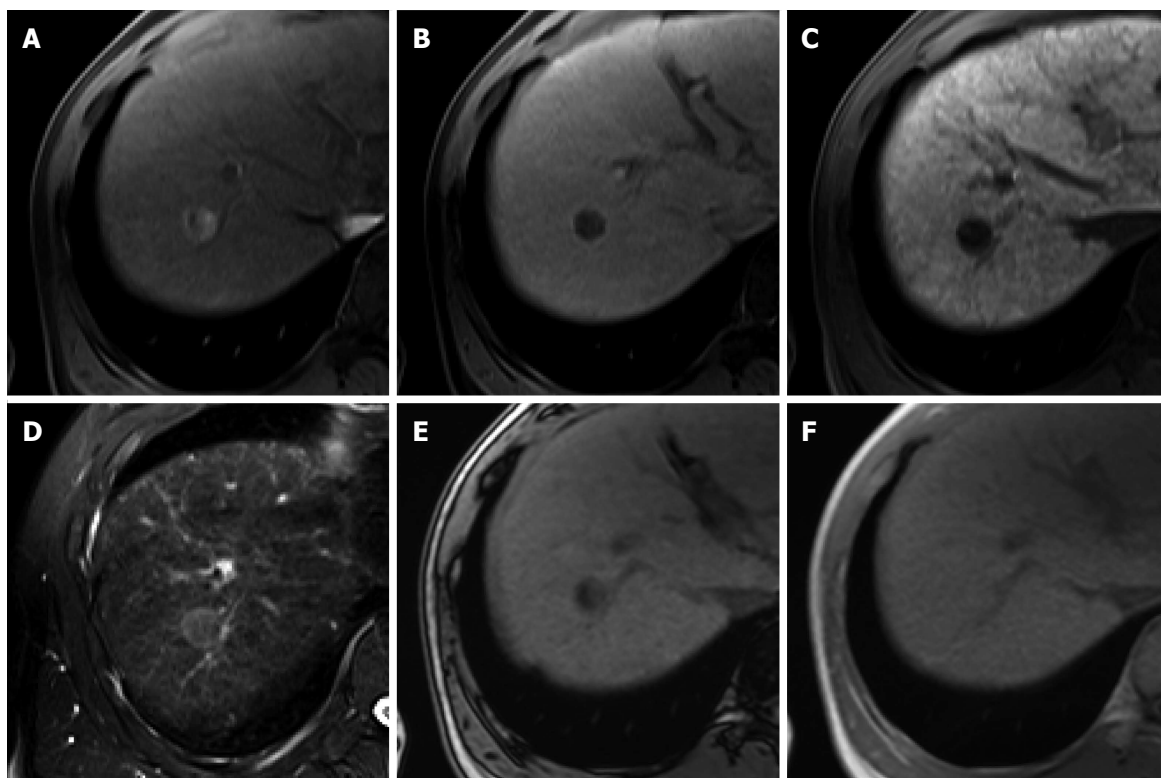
Fat-containing hepatocellular carcinoma in a 57-year-old man with hepatitis B infection. A: Hepatic arterial phase using gadoxetic acid shows heterogeneously arterial enhancement with intralesional low SI area; B: Transitional phase shows washout of the contrast medium in the tumor with capsular enhancement; C: Hepatobiliary phase shows marked hypointensity of the tumor relative to the liver parenchyma; D: T2-weighted image shows high signal intensity of the tumor; E, F: Opposed phase (E) and in-phase (F) T1-weighted gradient echo images reveals area of signal drop on opposed-phase image, indicating fat-containing lesion.
